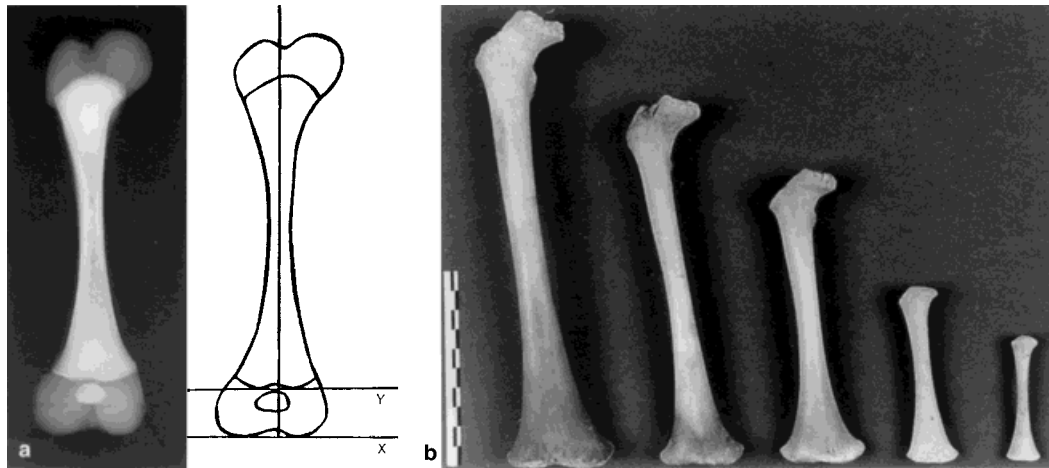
a: Femurs of a human newborn. On the left, radiography; on the right, representation of the infracondylar (X) and physeal (Y) planes. b: Femoral diaphysis of a 7-month fetus and of four children, 6 months, and 3, 5, and 7 years old. The proximal and distal epiphysis are
